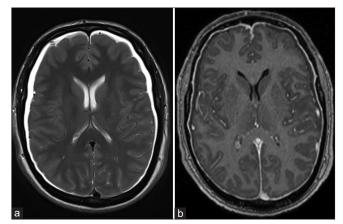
(a) High-signal fluid collections on axial T2-weighted magnetic resonance imaging (MRI) brain. (b) Diffuse pachymeningeal enhancement on axial T1 post contrast MRI brain, indicative of intracranial hypotension.
